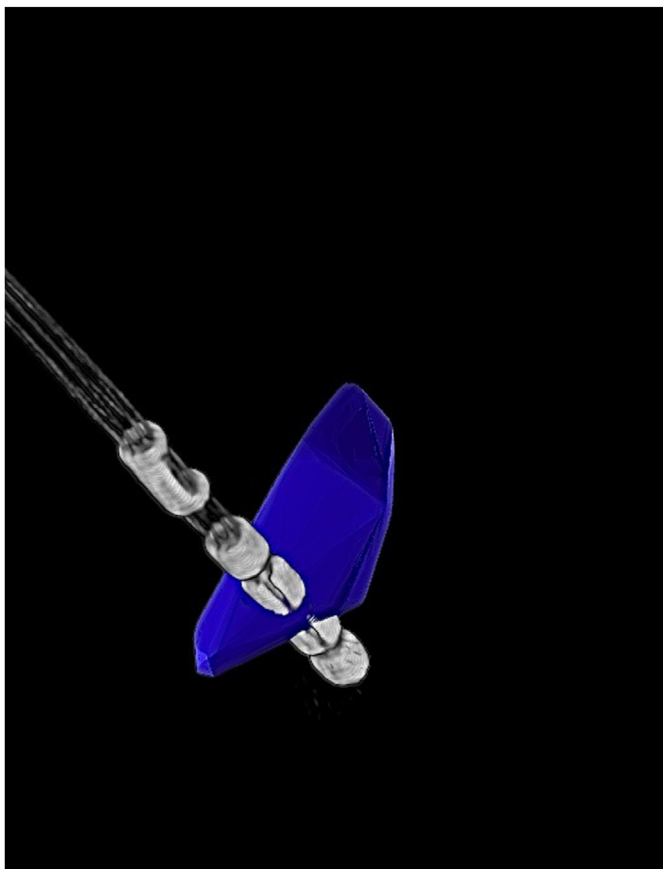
Boston Cartesia DB-2202 with segmented subthalamic nucleus figure. Postero-superior view: The segmented MRI contacts and their relationship to the STN (constructed from preoperative MRI FLAIR) can be readily appreciated and so easily used to anatomically optimize programming parameters. [Color figure can be viewed at www.neuromodulationjournal.org]
